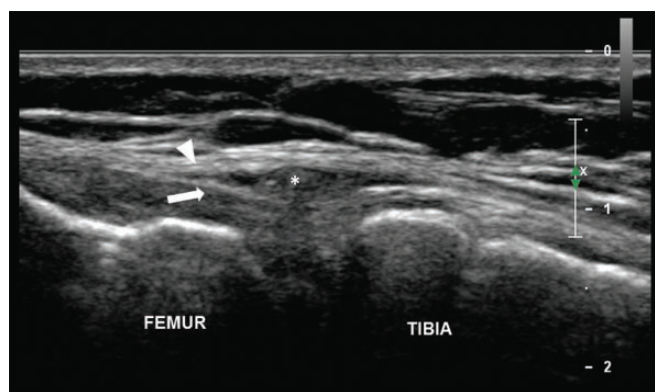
Case 2. Long-axis sonogram over the medial joint line. Inflammatory bursitis associated with meniscal suture material (asterisk) is seen lying between the superficial (arrowhead) and deep (arrow) layers of the medial collateral ligament.
